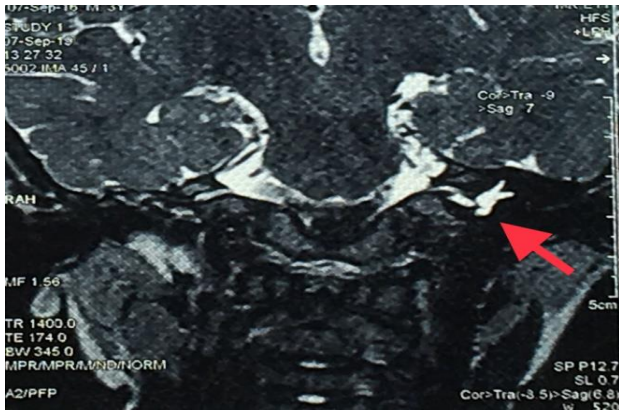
Magnetic resonance image of a 4-year old patient with absent cochlea on the right, but present on the left (red arrow).
